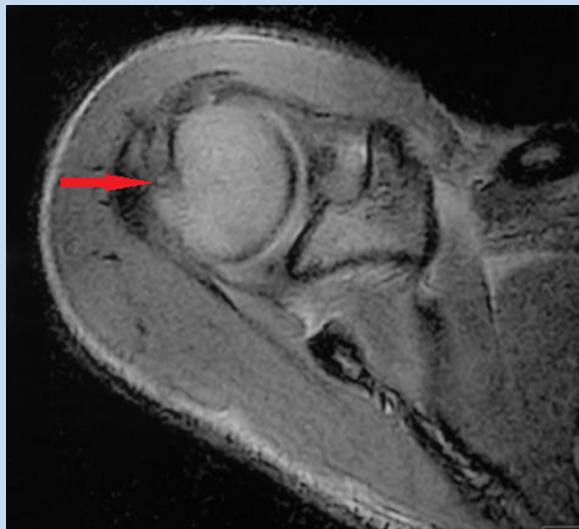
Axial magnetic resonance image showing a greater tuberosity fracture (arrow). There is no evidence of Hill-Sachs fracture.
